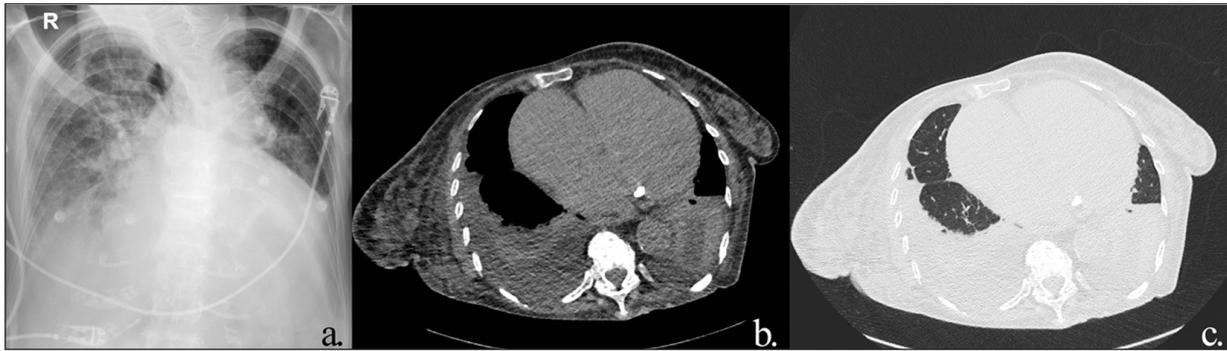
a) Chest X-ray, b) Non-contrast thorax CT mediastinum window, c) Non-contrast thorax CT parenchyma window images show, cardiac severe enlargement due to CCF, bilateral pleural effusion and compressional lung atelectasis. CT: Computerized tomography; CCF: Congestive cardiac failure.
